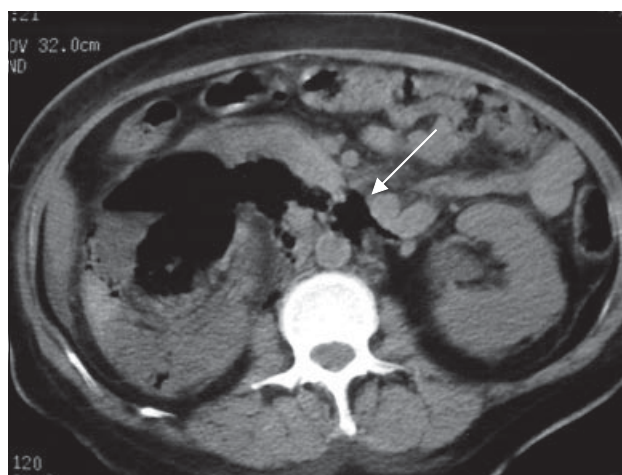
Non-contrast computed tomography of the abdomen at the level of the renal hilum showing gas in the right kidney and retroperitoneum outlining the aorta (arrow)
